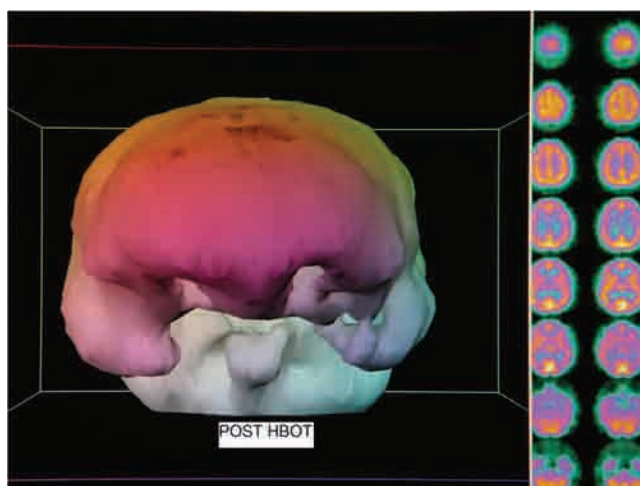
Post-HBOT SPECT brain scan three dimensional surface reconstruction and processed transverse images. Note relative improvement in brain blood flow to bilateral focal frontal and temporal defects and overall normalization of blood flow to a more homogeneous pattern.
